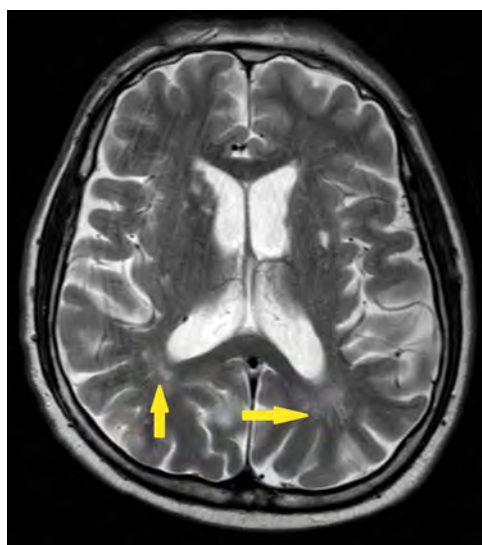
Yellow arrows show diffuse hyperintense millimetric ischaemic gliotic foci in the supratentorial white matter on brain magnetic resonance imaging T2-FLAIR sequence.
